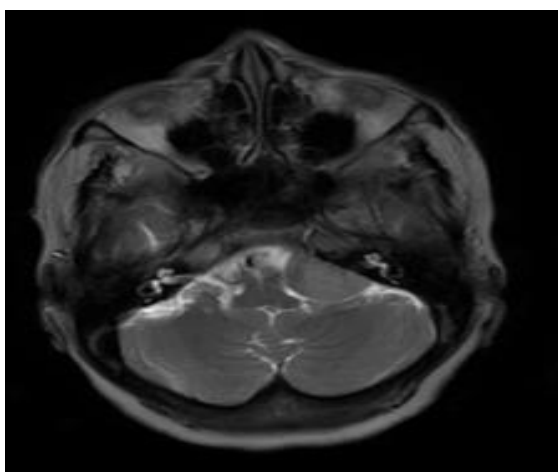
MRI T2 weighted image showing left CP angle Meningioma
